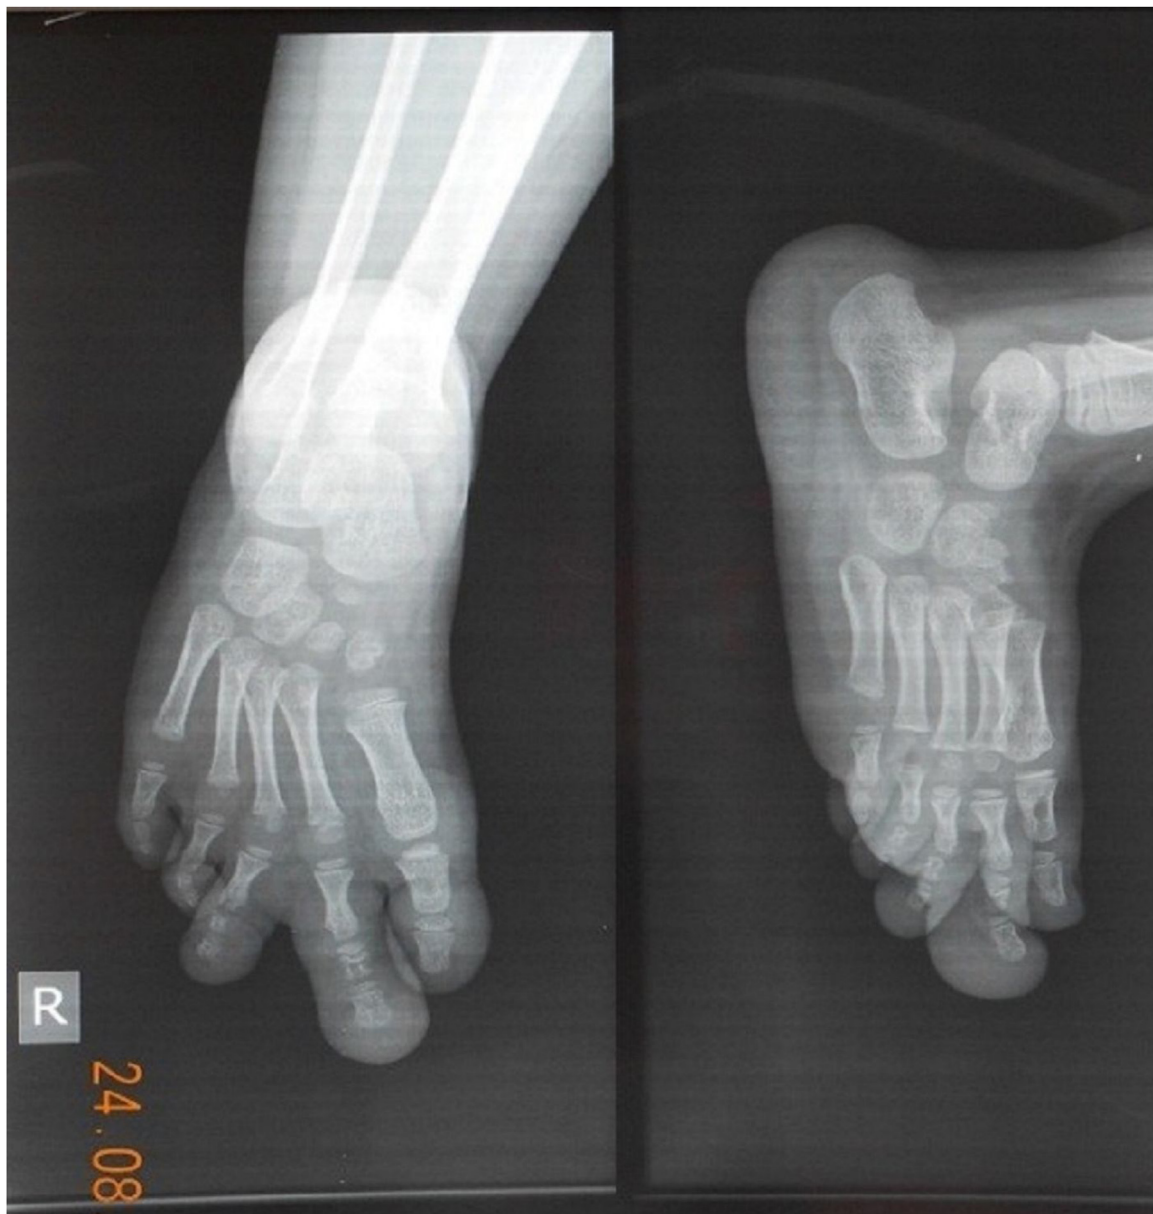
X-ray imaging before the surgery.
